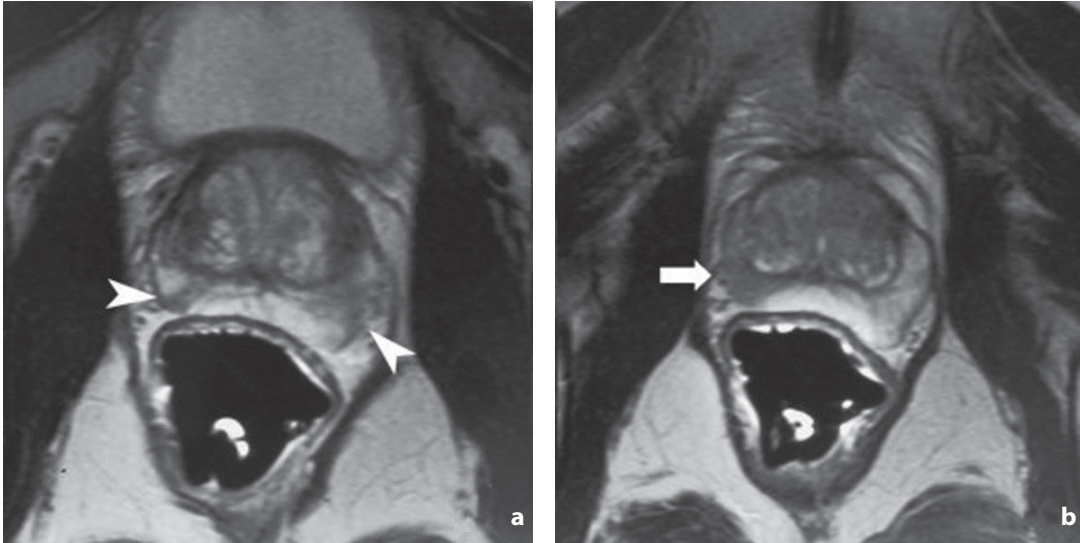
Magnetic resonance. Chronic prostatitis. a Axial T2-weighted image acquired at the middle third of the gland. In the peripheral zone, which is slightly asymmetric due to a retraction of the margin, a vague area of hypointensity can be seen (*arrowheads*) indicating postinflammatory tissue which in image b has a compact pseudonodular appearance (*arrow*), making differential diagnosis with carcinoma challenging
